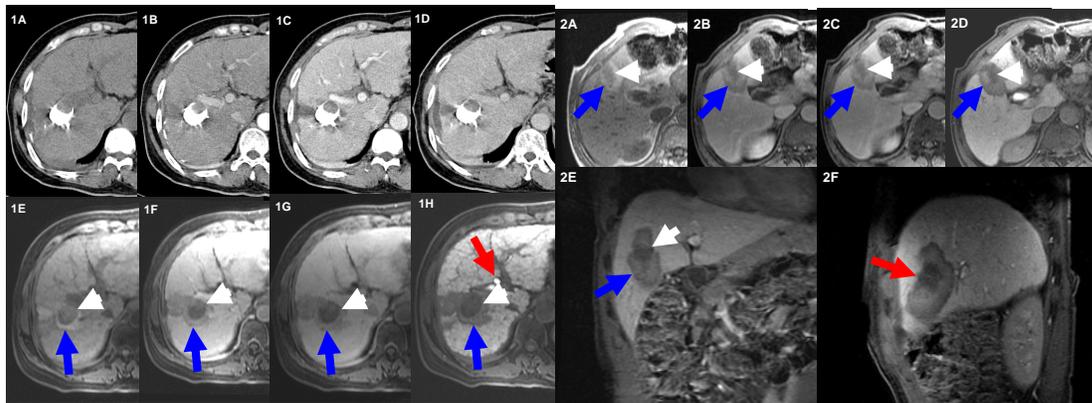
A 55-year-old woman having history of TACE performed RF ablation targeting viable HCC in washout site of Lipiodol. At MDCT performed at one day after RF ablation, there was not definite enhancing portion suspecting viable tumor in MDCT (Fig. 1A: precontrast, 1B: early arterial phase, 1C: portal venous phase, 1D: equilibrium phase), but not definite, because exact evaluation was difficult due to artifact associated with high density Lipiodol. Gadoxetic Acid (Gd-EOB-DTPA)-enhanced MRI definitely revealed peripheral tumor margin (white arrow) and ablation margin (blue arrow) without definite enhancement on precontrast (1E), early arterial phase (1F), portal venous phase (1G), and 30 minutes delayed phase (1H). Biliary contrast excretion was identified on 30 minutes delayed phase (1H, red arrow). The CT performance for differentiation of treated margin and tumor margin was fair in reader 1, intermediate in reader 2, but the MR imaging performance for conspicuity of tumor margin was excellent in both readers. For evaluation of remnant or residual tumor in CT was intermediate degree in both readers and that in MR imaging was definitely absent in both readers.
